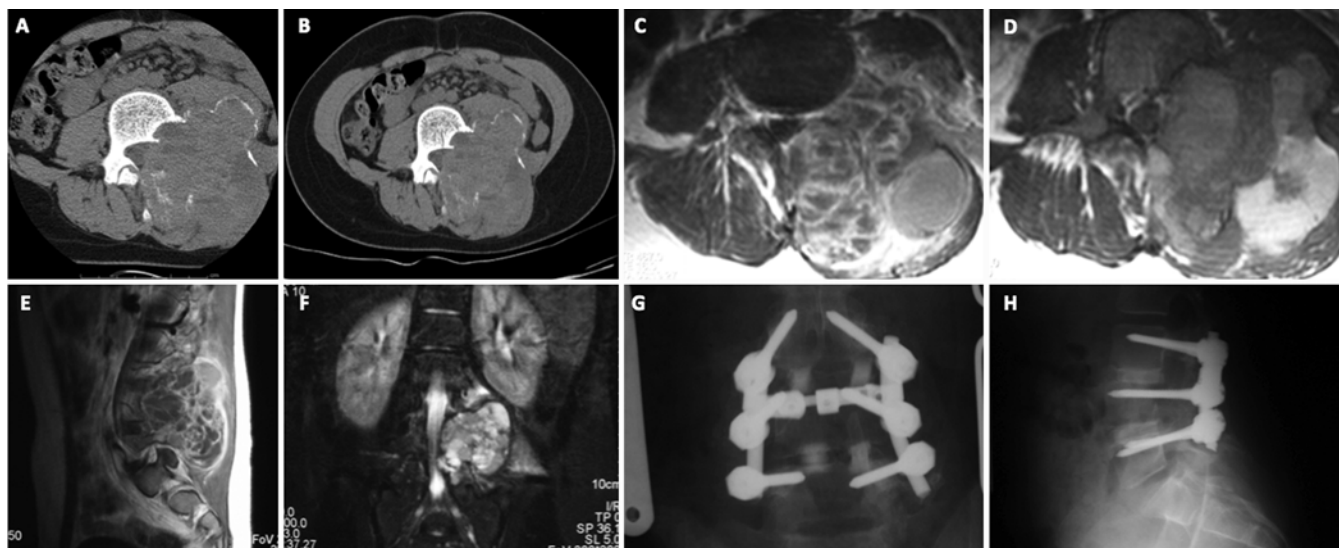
Case 8. Images obtained in a patient with L4 anterior involvement. Axial CT scans (A and B) showing extensive involvement of the left posterior elements of L4 with significant paraspinous extension and distortion of the anatomy. Axial (C and D), sagittal (E) and coronal (F) MR images delineating the extensive soft-tissue involvement. Anteroposterior (G) and lateral (H) plain radiographs of the lumbar spine were obtained 9 years after surgery, which involved an L4 and partial L3 vertebrectomy, an L3–5 fusion with L3–4 and L4–5 posterior lumbar interbody fusion, iliac crest bone grafting, and pedicle screw fixation using the Synthes system.
